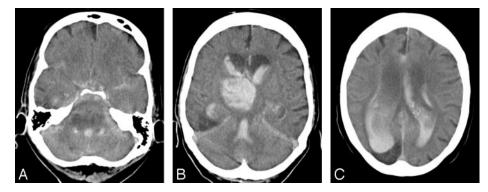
Unenhanced cranial CT from approximately 1 hour after the intervention demonstrates a large right basal ganglial hemorrhage with extension to intra-axial and extra-axial CSF spaces. The hematoma is ipsilateral to the treated stenosis. The uppermost section shows the residual lesion after previous infarction in the right PCA territory.
